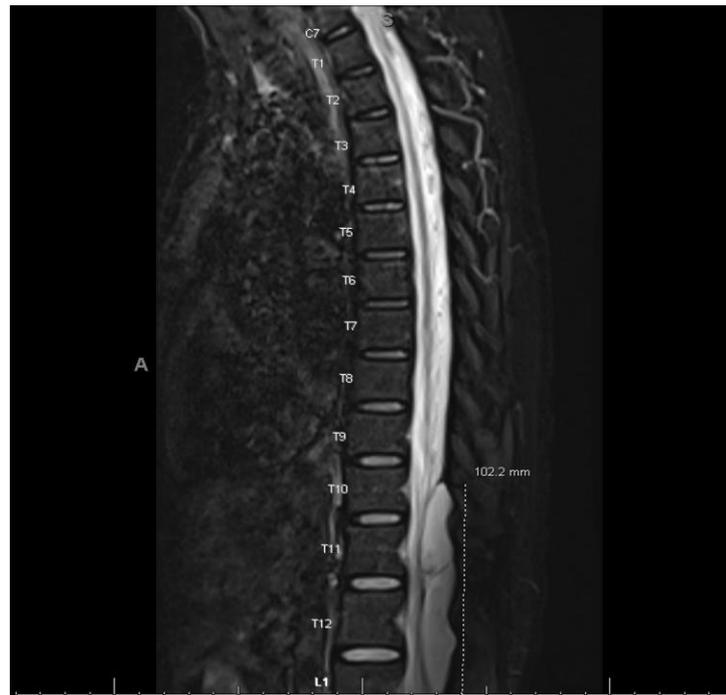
Sagittal STIR MRI without contrast demonstrating a large SEAC spanning from T11 to L1.
